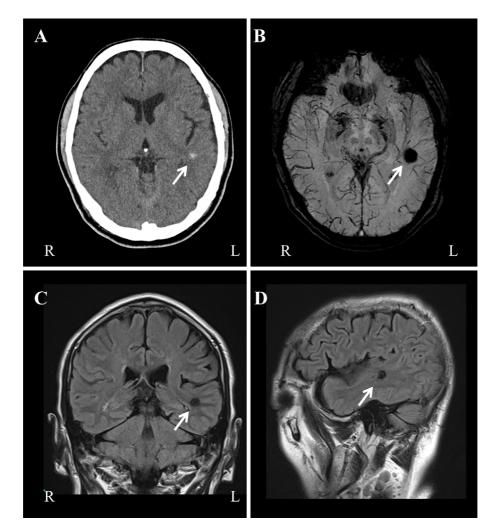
Head computed tomography image showing a hyper-dense area in the left superior temporal gyrus (STG). B: Transverse susceptibility-weighted image. C: Coronal fluid-attenuated inversion recovery (FLAIR) image. D: Sagittal FLAIR image. Each white arrow shows a hyper-dense area located in the left STG. The area is consistent with a cavernous hemangioma.
